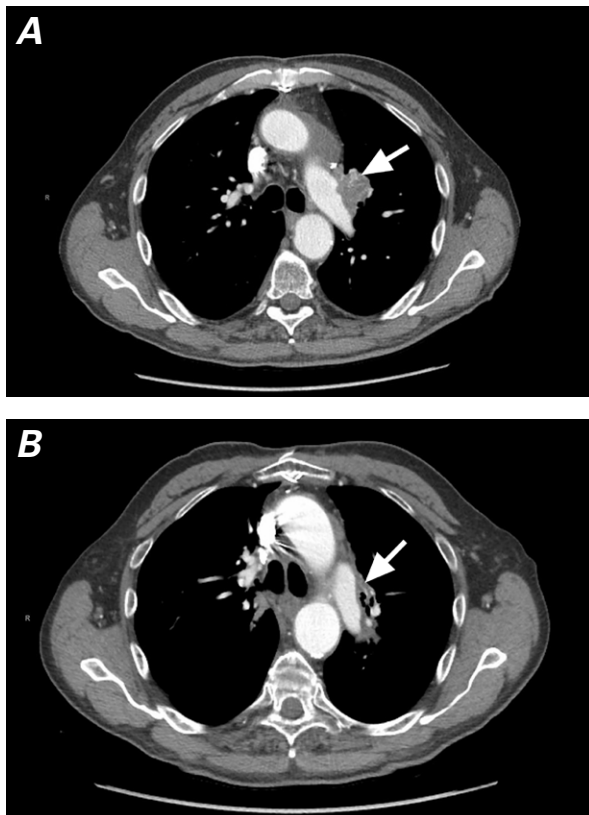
Computed tomograms of the chest show the tumor (arrows) A) before and B) after postoperative chemotherapy and radiation therapy.
